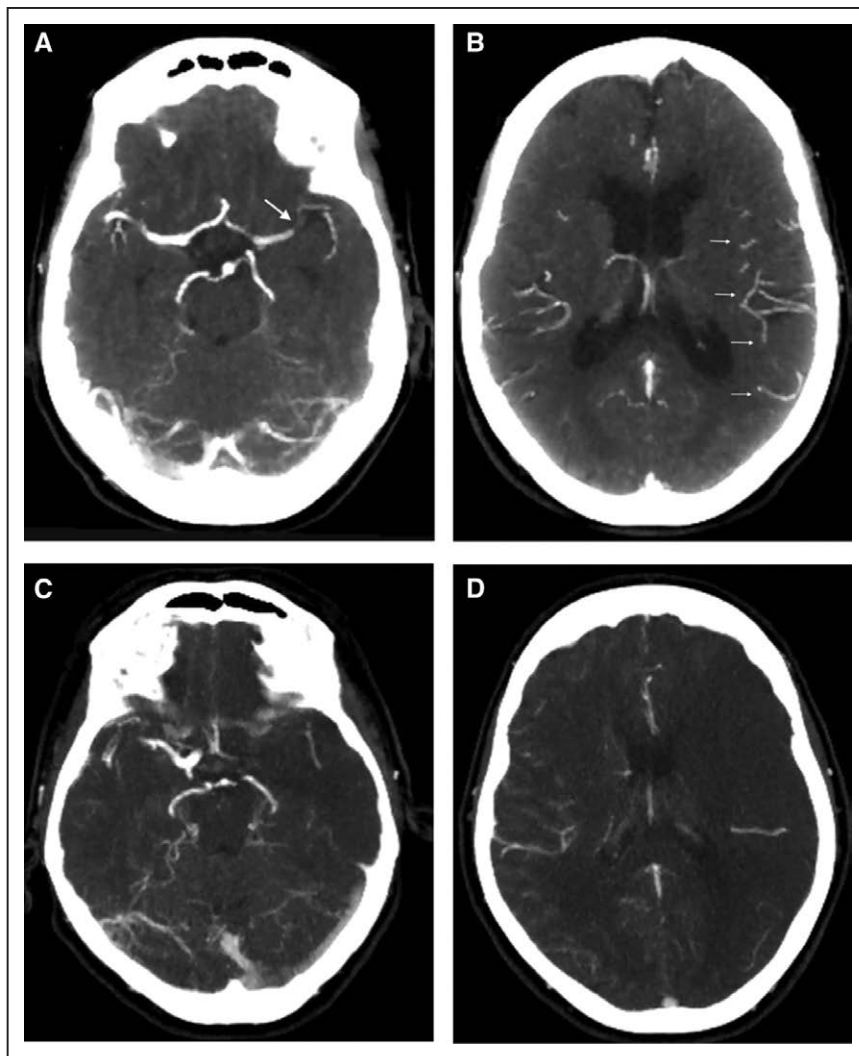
Computed tomographic angiography (CTA) in acute ischemic stroke. A, Occlusion of the left middle cerebral artery (arrow). B, Good leptomeningeal collateral status (white arrows). C and D, Poor collaterals in left hemisphere stroke after terminal internal carotid artery occlusion predicting unfavorable outcome.
